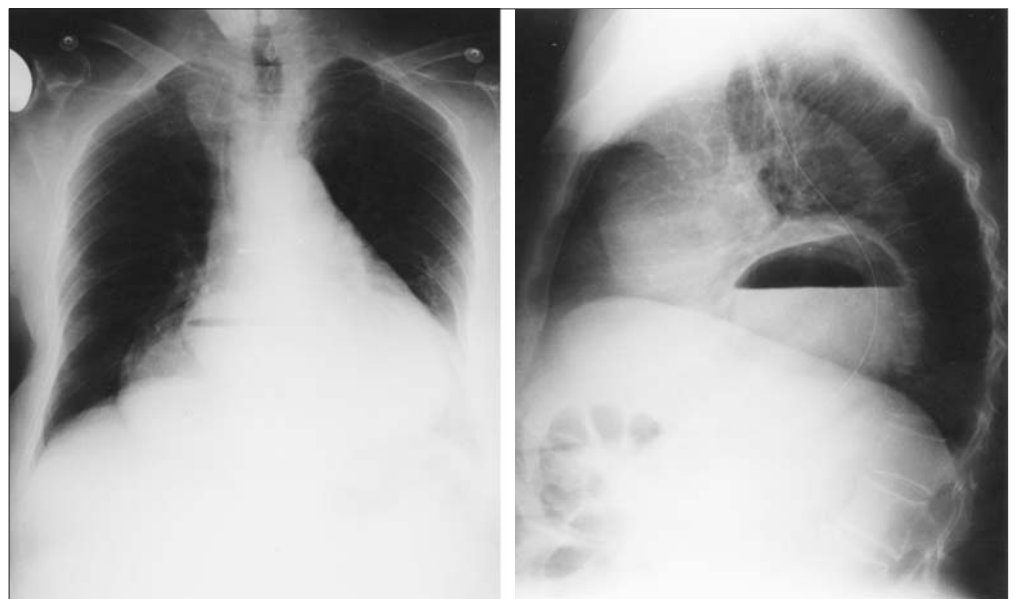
Chest x-ray. Erect PA (left) and lateral (right): Large intra-thoracic hiatus hernia with associated air-fluid level. Nasogastric tube has its tip in middle part of the stomach.
